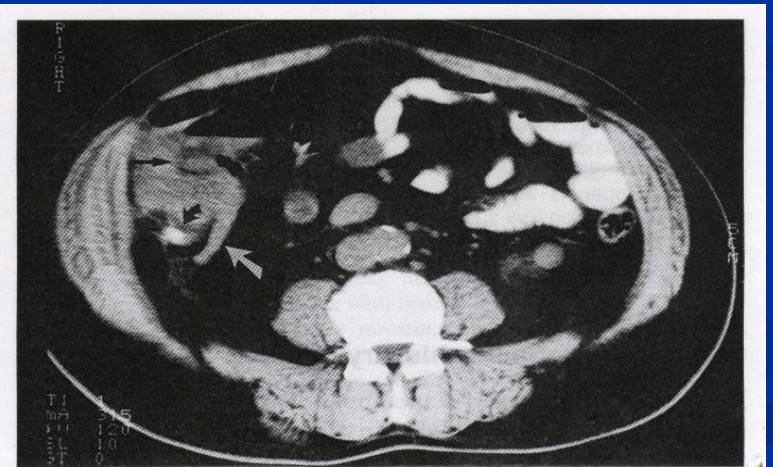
Abdominal CT showing faecolith of the appendix (black curved arrow), distended appendix (white arrow) and phlegmonous mass surrounding tip of the appendix (straight arrow) (courtesy of Dr Denis O'Connell, Dublin, Ireland).
